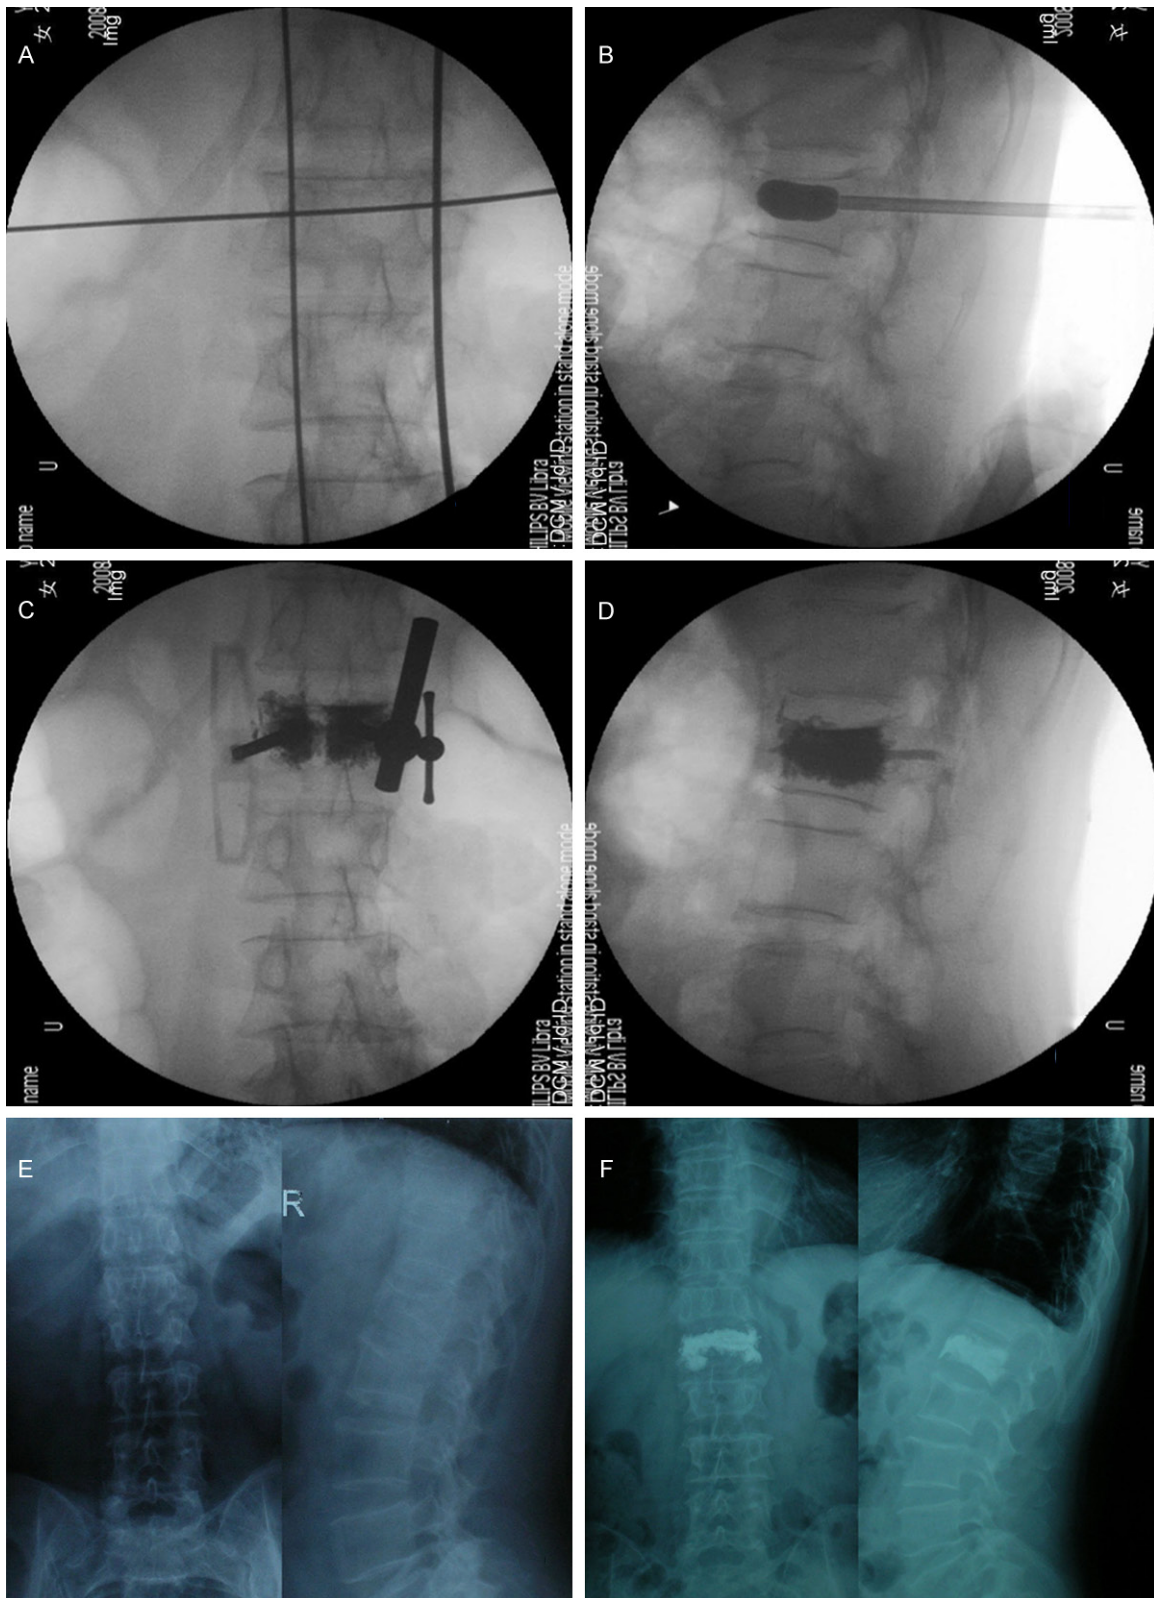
Data of a percutaneous balloon kyphoplasty case. A: The projection points of bilateral pedicles on the posterior aspect were located under C-arm fluoroscopic guidance; B: The balloon was dilated after successful puncture; C: Anteroposterior and lateral radiographs of the thoracolumbar spine after injecting bone cement; D: Postoperative lateral view of fluoroscopy; E: An OVCF case involving L1 (PKP was performed); F: Anteroposterior and lateral radiographs of the thoracolumbar spine obtained one year after surgery showed that the reduction of the affected vertebra was excellent and there was no loss of correction in vertebral height.
